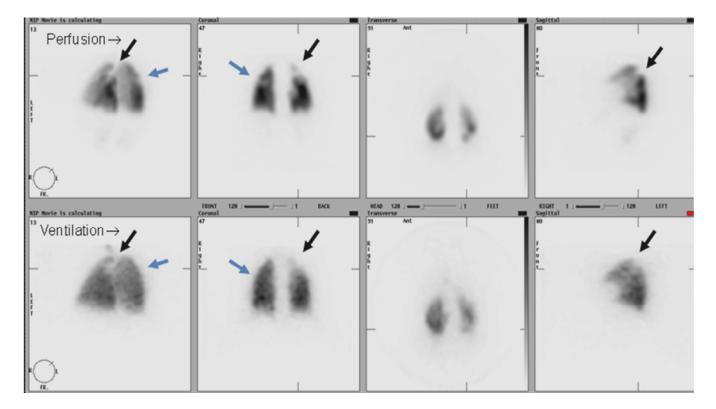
Case One (Below V/Q SPECT MIP images)
